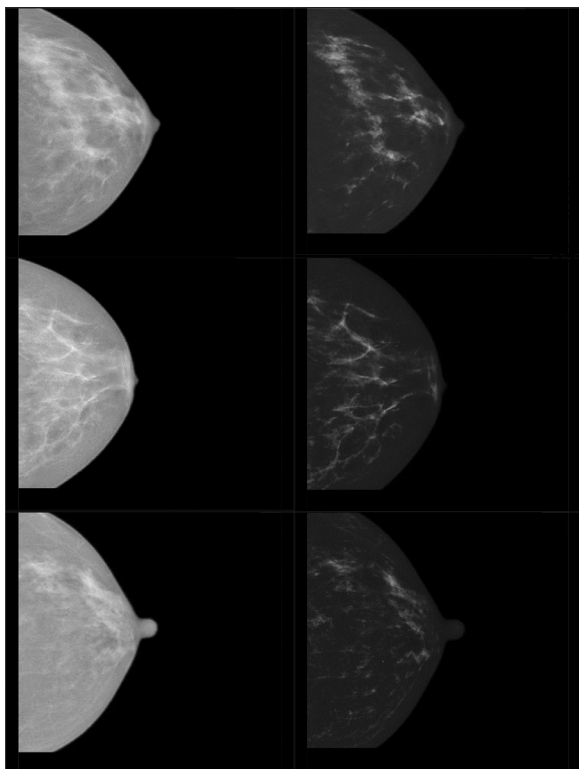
RICE applied to intensity based mammograms(DICOM x-ray images).
